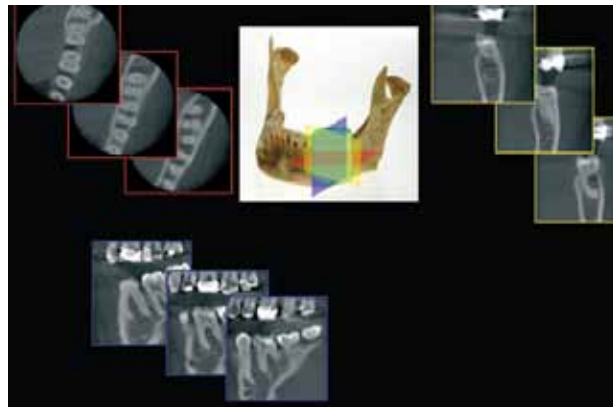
All cone-beam tomography units provide correlated axial, coronal and sagittal multiplanar volume reformations. Basic enhancements include zoom or magnification and visual adjustments to narrow the range of gray-scale, in addition to the capability to add annotation and cursor-driven measurement.
